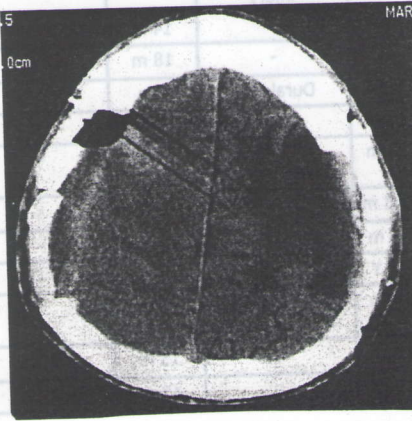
Postoperative brain CT.
